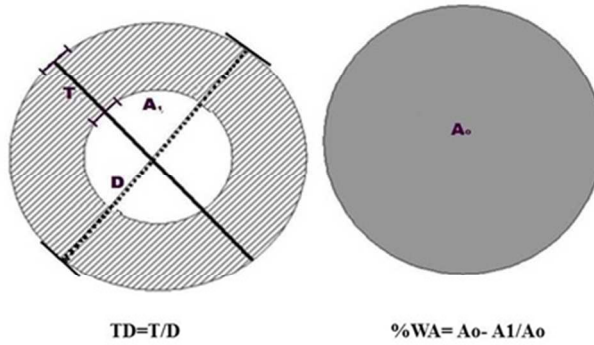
Subsegmental HRCT sections for bronchial wall thickness
